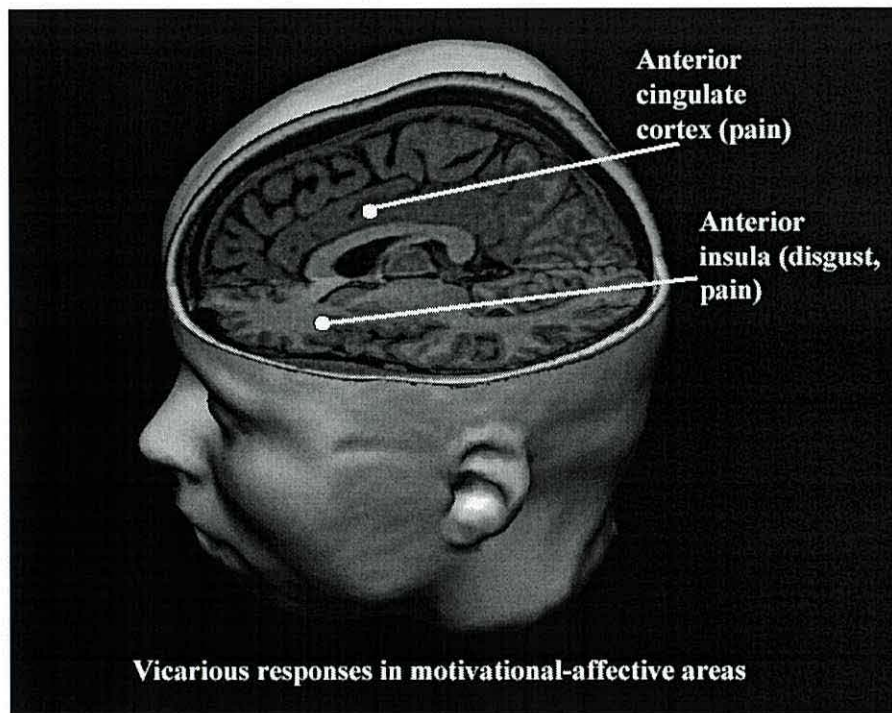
A cutaway view of the brain showing areas in which vicarious responses have been observed in the medial cingulate cortex (for pain) and the anterior insula (for olfactory disgust and pain). These two areas are important in relating bodily information to potential behavioral responses. (Rendered MRI image shows $x = -1$ and $z = 4$ in Talairach space.)
